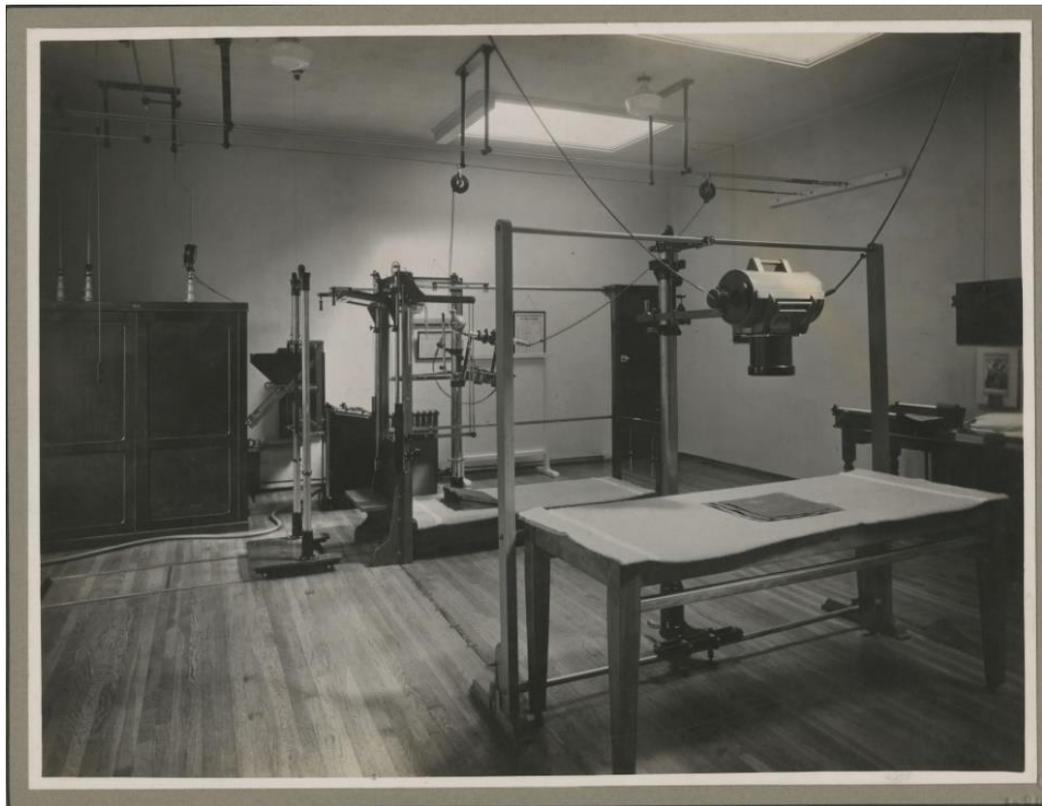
X-ray room, Stannington Sanatorium, c.1936 (HOSP/STAN/11/1/15)
